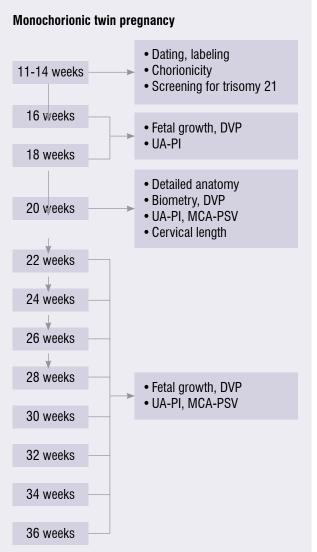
Ultrasound monitoring pathway in uncomplicated monochorionic twin pregnancy $^{7]}\!$
